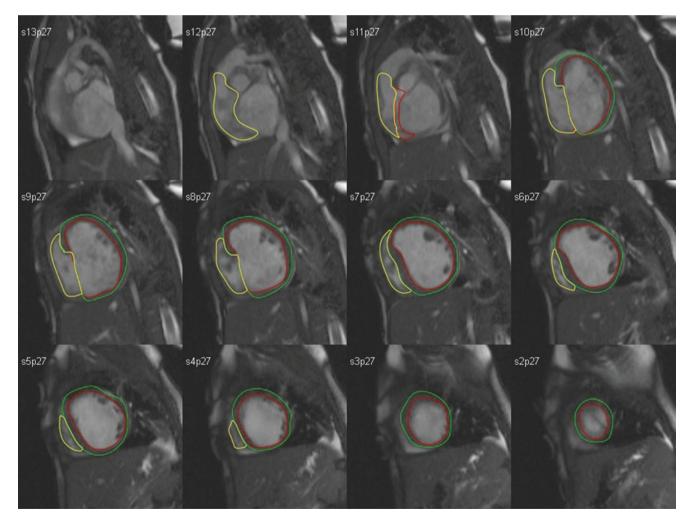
MRI-derived volumetric measurement of an unbalanced atrioventricular septal defect/DORV. Total ventricular volume is determined by the summation of volumes of a series of short-axis stack
